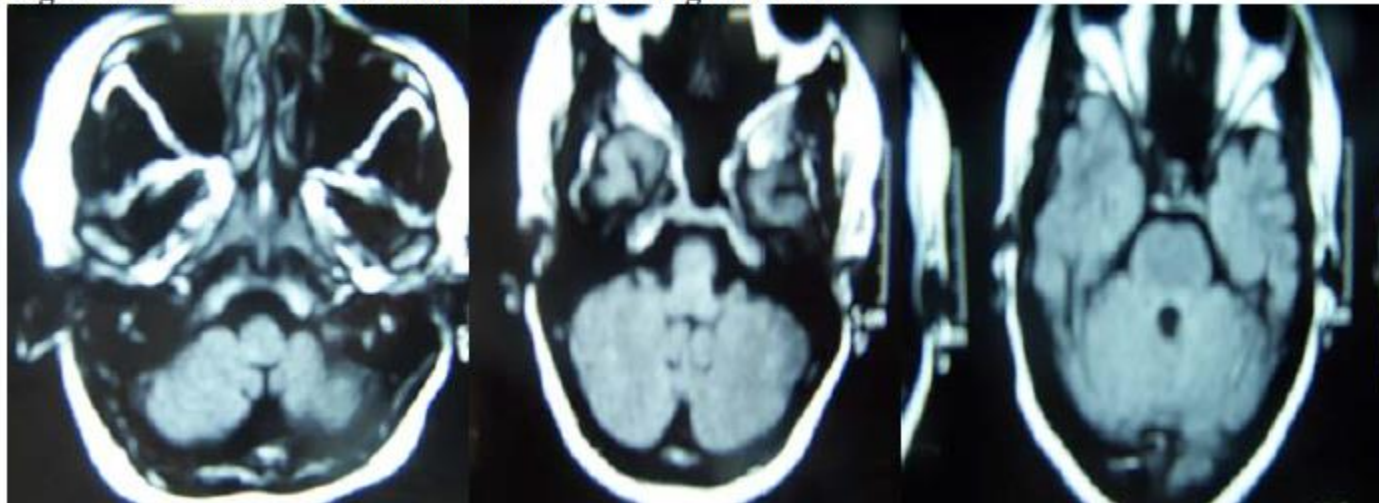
MRI of the Brain 5 months after starting treatment
